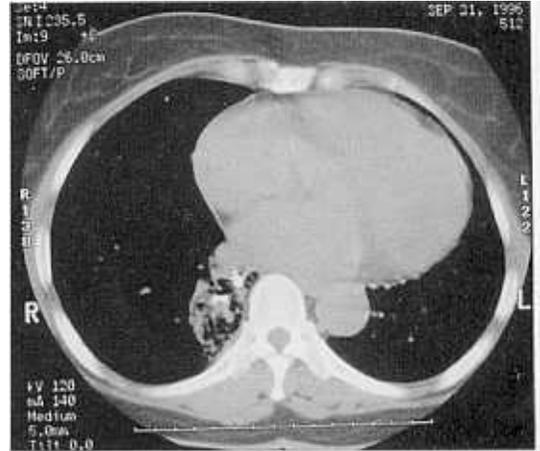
Chest CT scan shows complete collapse of the right lower lobe basal segment with bronchiectatic change and calcifications, probably due to old inflammatory sequelae, but no definite fistulous tract is shown.
